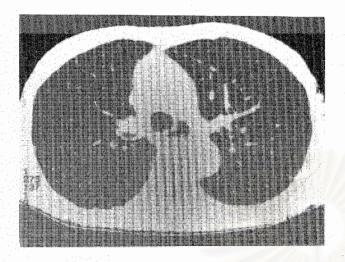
Inspiratory HRCT of case 1 shows numerous small round and branching linear opacities throughout both lungs, typical of the 'tree-in-bud' pattern of small airway disease. Slight dilatation of small bronchi is also seen.
